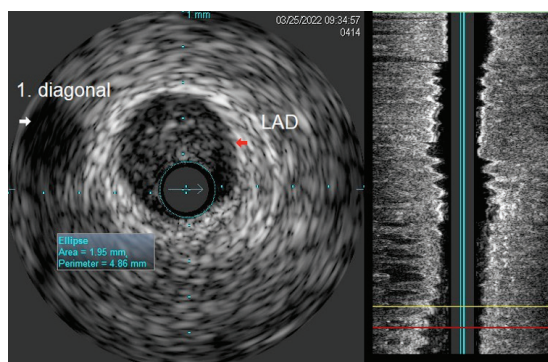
Intravascular ultrasound of LAD stenosis
